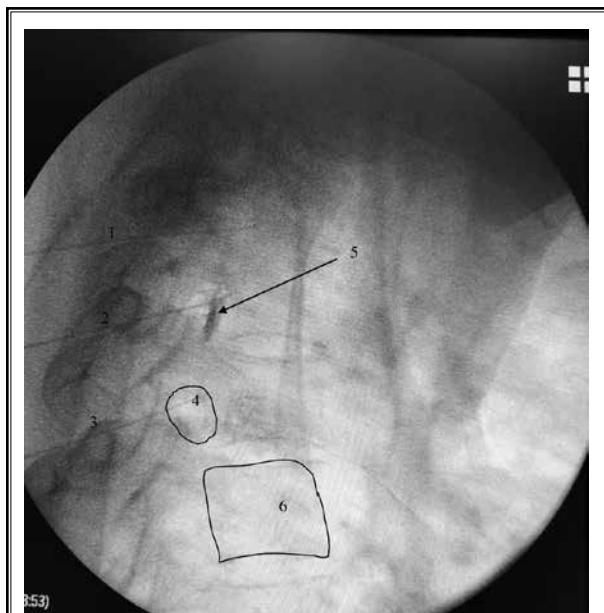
Lateral x-ray view of the upper thoracic spine depicting the DRG procedure. 1, 2, and 3 = the RF needles targeting the second, third, and fourth thoracic DRG (from above downward). 4 = the fourth intervertebral foramen. 5 = the dye delineating epidural spread. 6 = the fifth thoracic spine.
